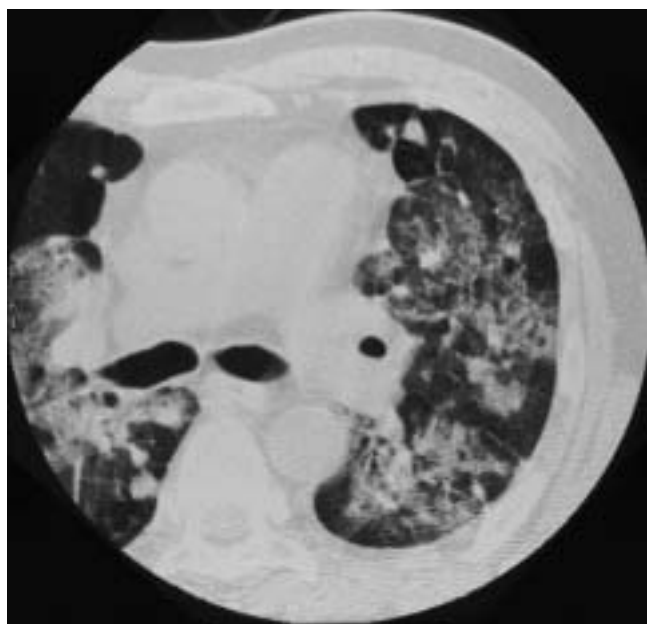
Chest computed tomography scan demonstrating bilateral ground-glass attenuation and right lung cancer with multiple pulmonary metastases.
